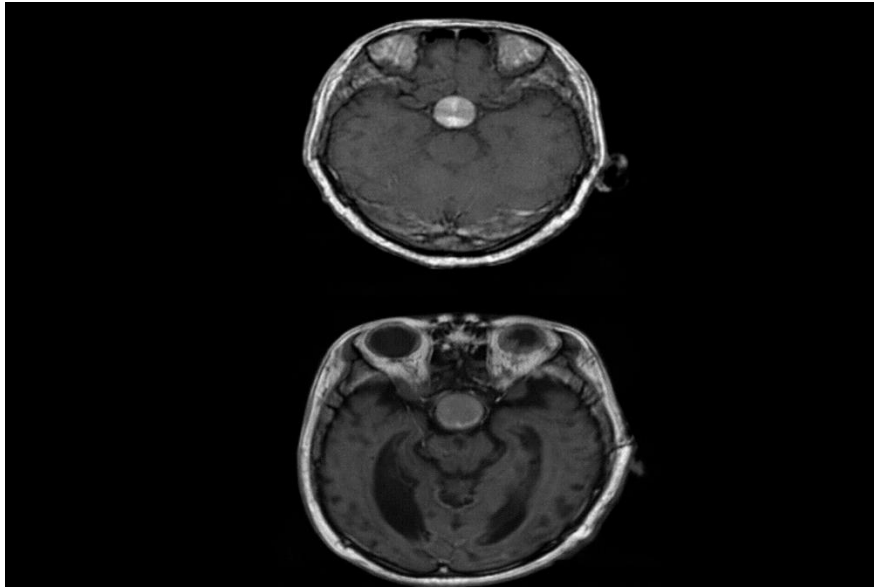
Brain Tumour MRI Images (Pituitary Tumour) (Hashemzahi et al., 2020).
